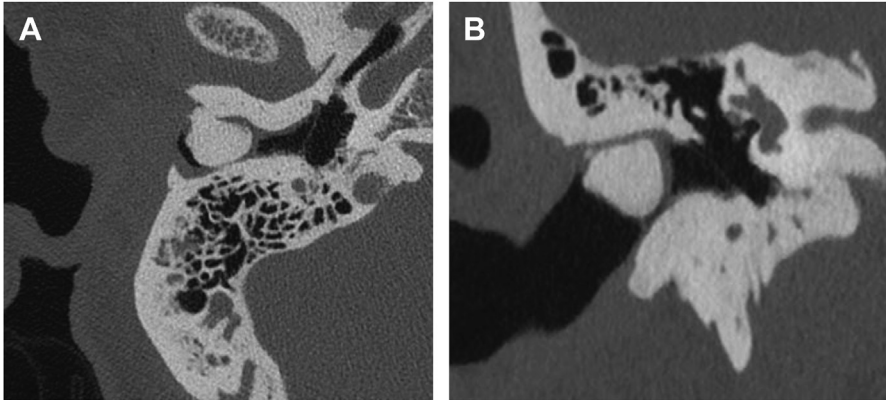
High resolution CT temporal bone of the right external auditory canal in the axial (A) and coronal (B) planes demonstrating a large superiorly based osteoma originating from a relatively narrow stalking, causing near complete canal occlusion.
